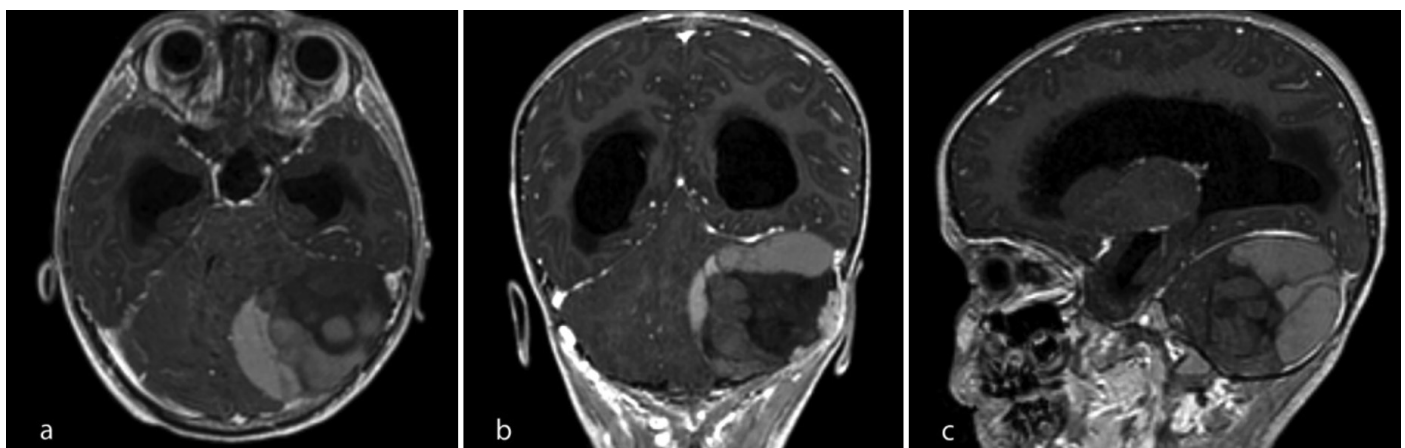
Contrast MRI of the patient with Ewing sarcoma/PNET tumor; a) axial, b) coronal, c) sagittal sections
